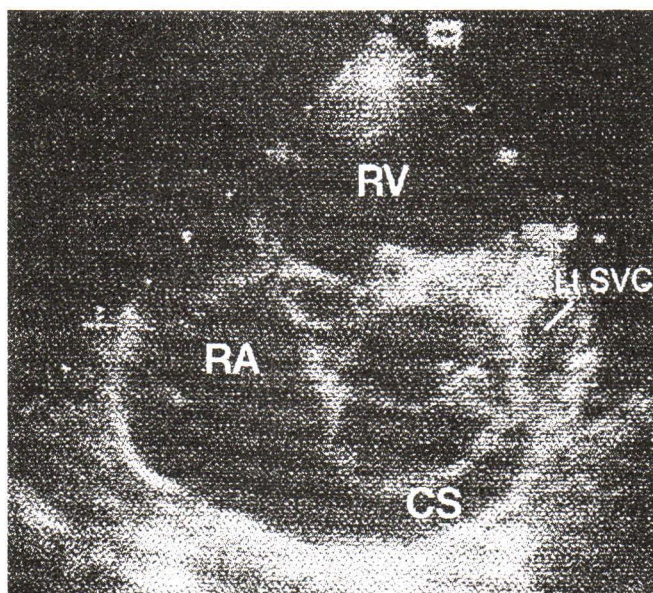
Demonstrates modified parasternal short axis view. CS = coronary sinus, LtSVC = left superior vena cava, RA = right atrium, RV = right ventricle.
